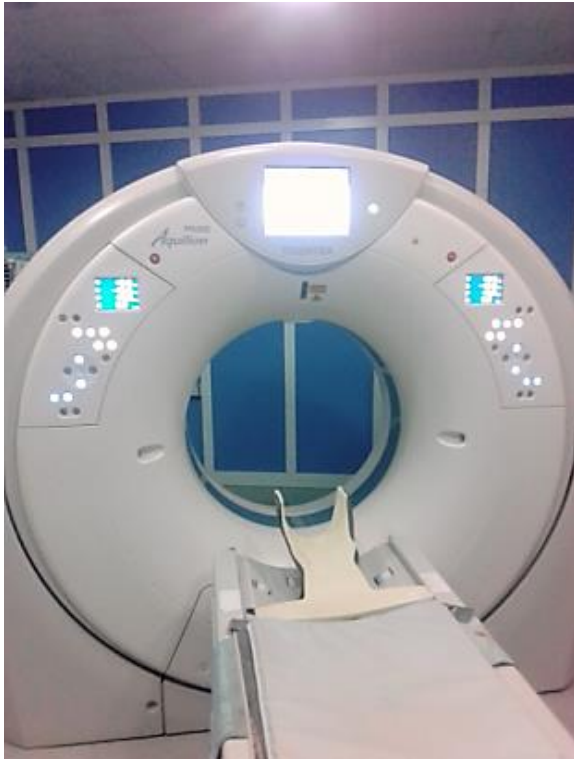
164 Slice CT Scanner at Muhammadu Sunusi II Radio-Diagnostic Center, AKTH.
